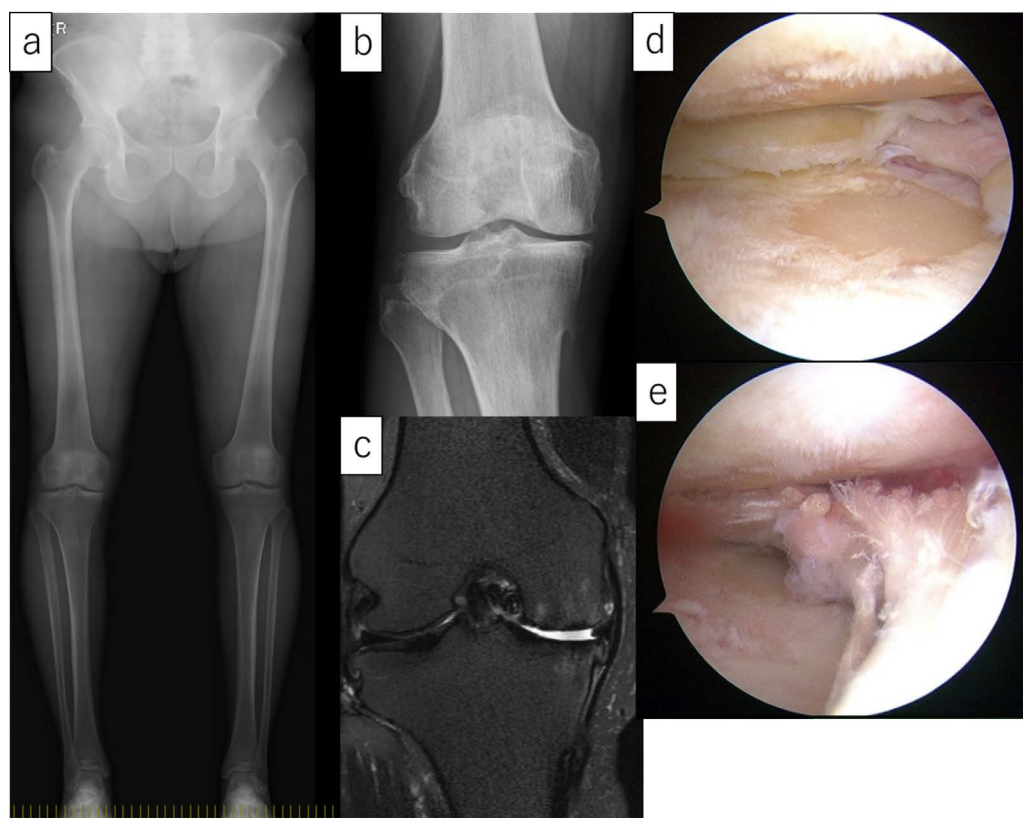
a) Standing radiograph of the lower extremity; b) Standing radiograph of the right knee; c) Coronal view on magnetic resonance imaging; d) Arthroscopic view of the medial compartment prior to and post meniscal reconstruction; e) Arthroscopic view of the medial compartment prior to and post meniscal reconstruction.
